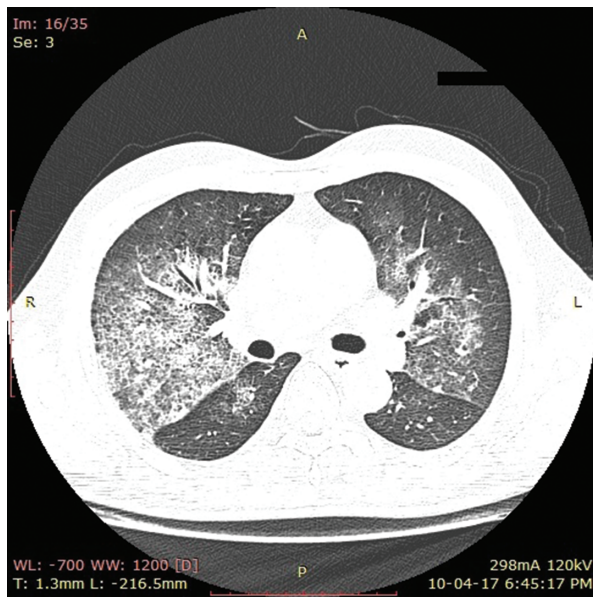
Chest computed tomography (CT) scan demonstrates perihilar ground-glass opacities of both lungs with right upper lobe predominance, thickening of interlobular septa and intralobular lines, and diffuse bronchial wall thickening.
